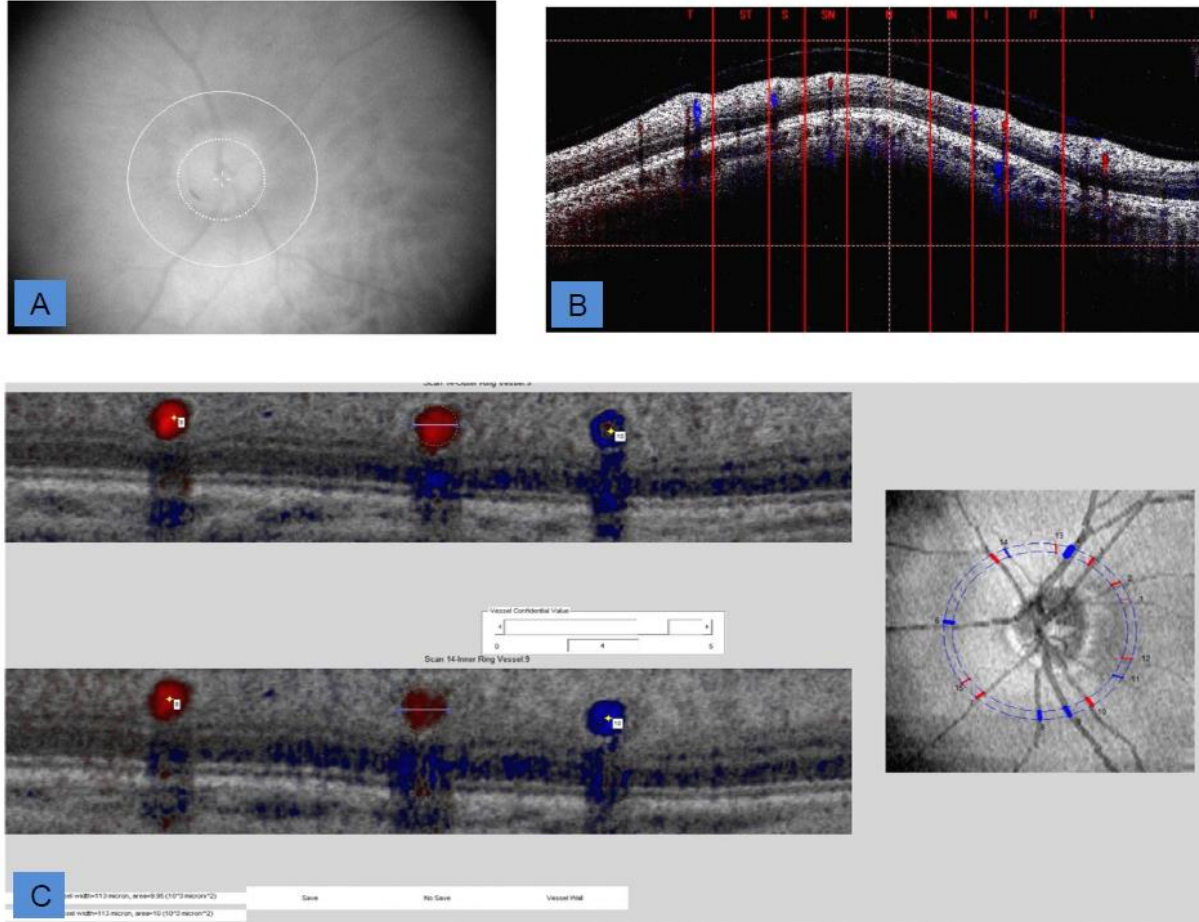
A) Scanning laser ophthalmoscope (SLO) image during the Doppler imaging, with the double para-papillary circular scan centered on the ONH. B) A still image of the real-time video of the ONH during the Doppler imaging, with the OCT beam positioned at the superonasal pupil location. C) A print-screen of the DOCTORC software during the analysis of one of the vessels, the top strip shows the vessels transected by the outer circular ring scan, and bottom strip for the inner circular ring scan. The smaller ONH image on the right shows the double circular scan transecting the retina in two different locations. The vessels were manually refined for their location, boundary and type (artery or vein). All these attributes, together with the Doppler signal strength and Doppler signal agreement were given a confidence score, following the guidelines in the DOCTORC grading protocol.
